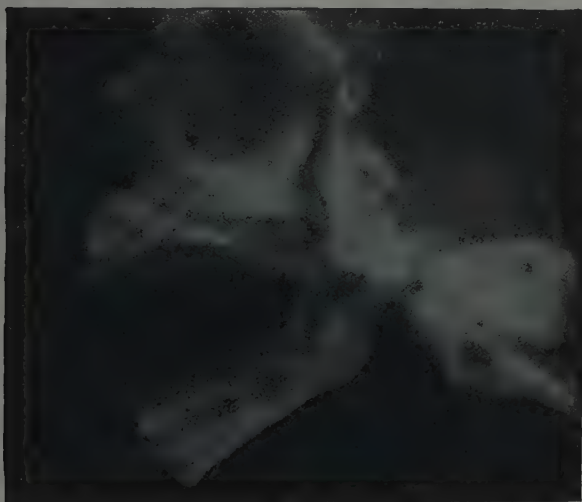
X-ray photograph of the skull of a baby at birth, showing the unerupted teeth, still incompletely calcified, inside the jaws. (From Symington and Rankin's "Atlas of Skiagrams," with permission of Longmans Green and Co.)
